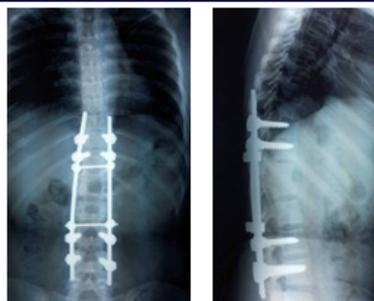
(A-F) 24 year old female with tuberculous spondylodiscitis T12-L1. (A-B) anteroposterior and lateral radiographs showing destruction of vertebral bodies T12-L1. (C-D). Sagittal and axial MR images showing collapse of vertebral bodies with subsequent kyphosis and spinal canal compromise. (E-F). Post-operative images showing restoration of sagittal balance and posterior instrumentation with pedicle screws and rods
